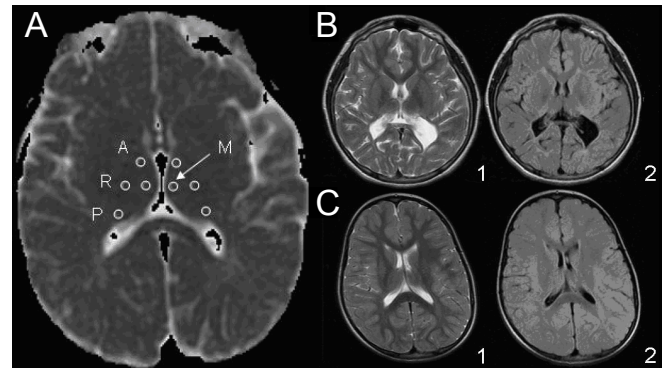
Manual Traces of Anterior(A), Reticular(R), Pulvinar(P) and Medial Dorsal(M) thalamic nuclei are shown. B,C: T2 (1) and FLAIR (2) images for severe PVL (B) and mild PVL (C). The severity of each case is evident from the degree of periventricular white matter volume loss.
